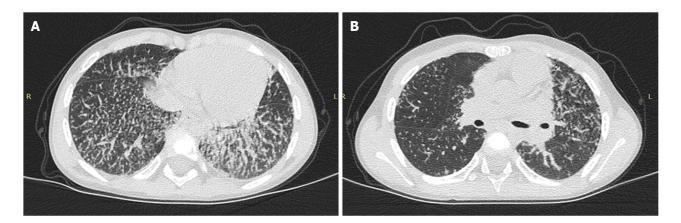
Chest computed tomography in patient 2 with lipoid pneumonia. A and B: Representative signs of interstitial changes in all lobes of the lungs with damage to the distal parts of the tracheobronchial tree. There are diffuse changes with the presence of multiple intralobular foci, with thickening of the peribronchovascular interstitium.
